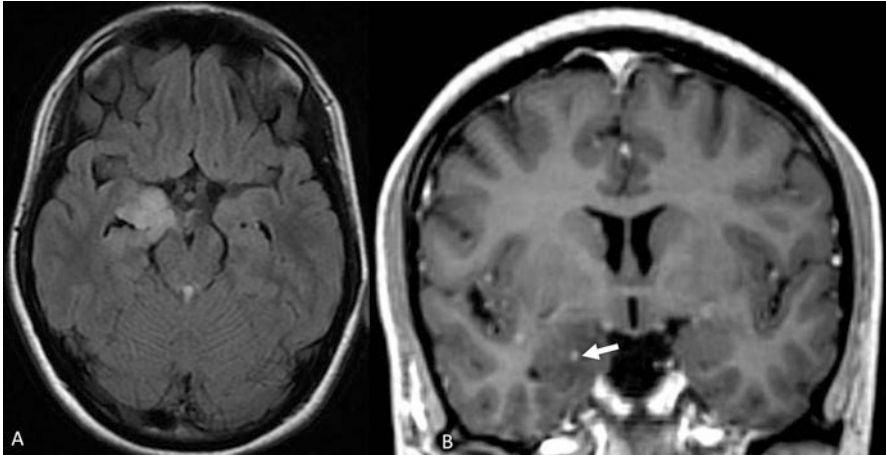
Partially delineated nodular appearance of a type 2 DNT with signal increase in axial FLAIR (a) and hyposignal in T1 with a small punctate contrast enhancement after gadolinium infusion (b arrow)
